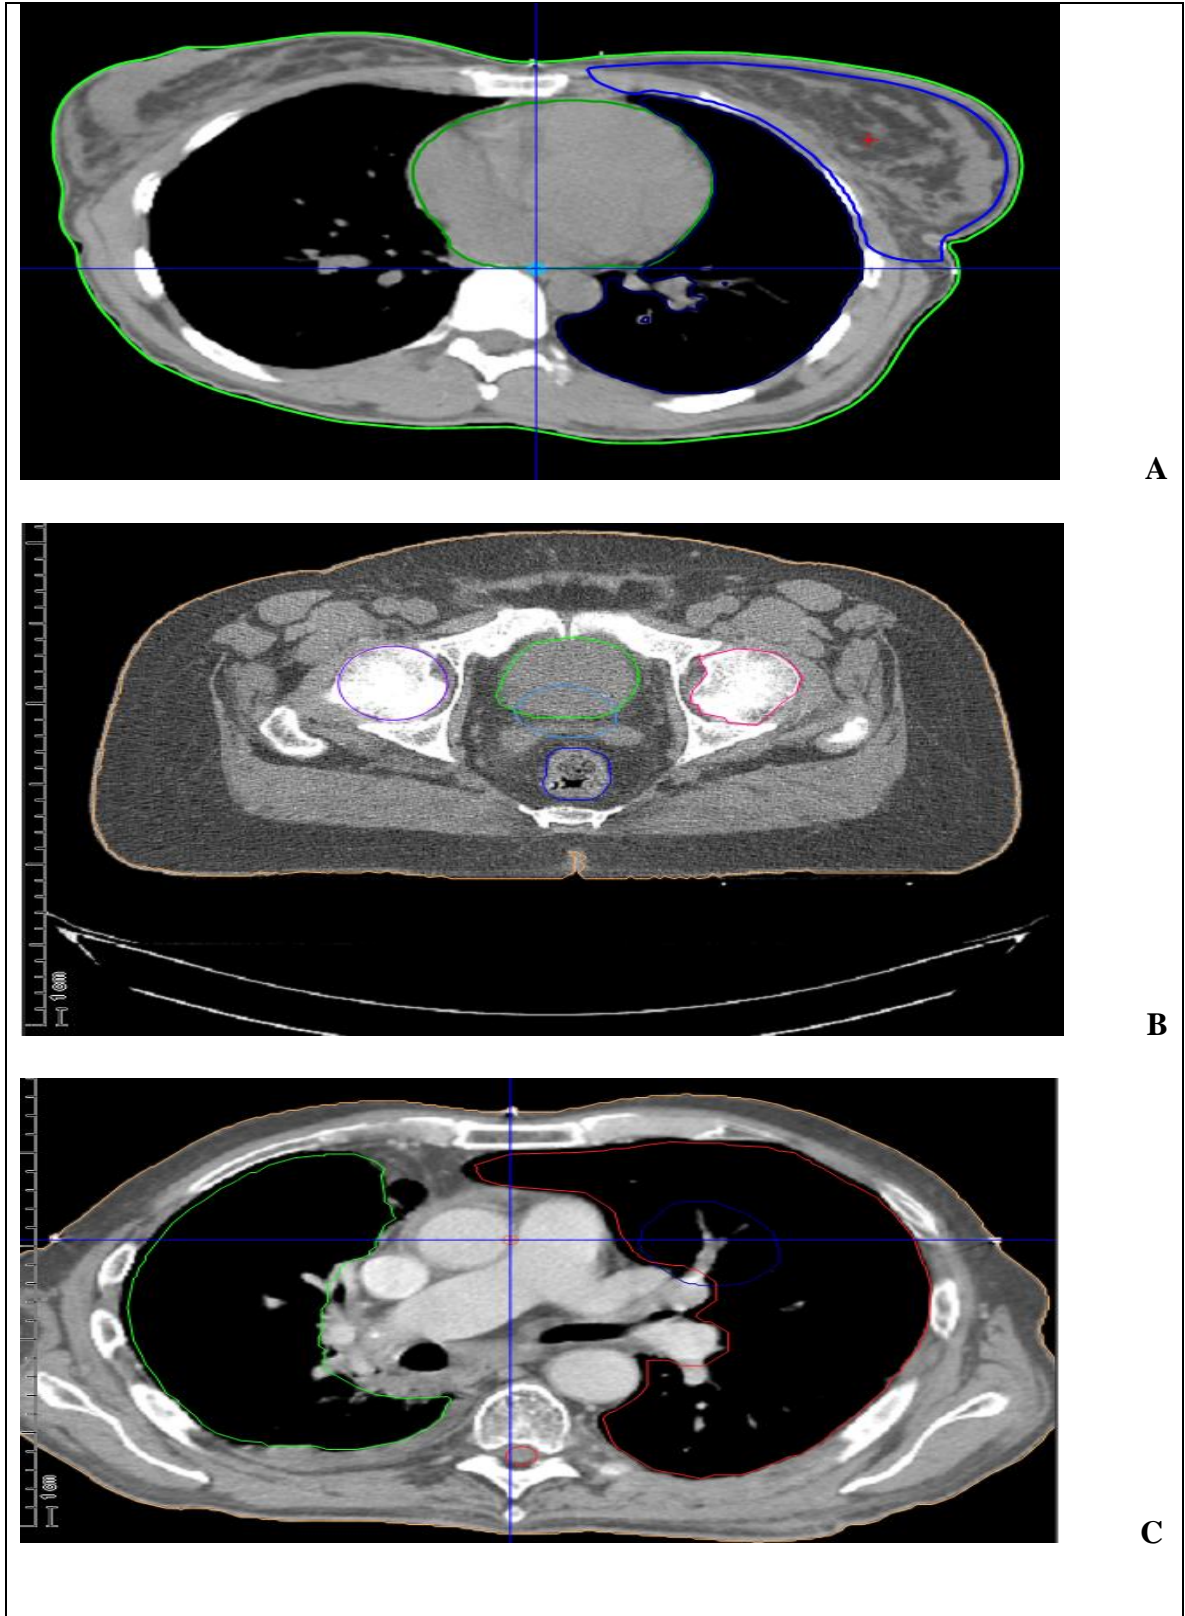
Retrospective CT slices (A) Breast (B) Prostate (C) Lung
